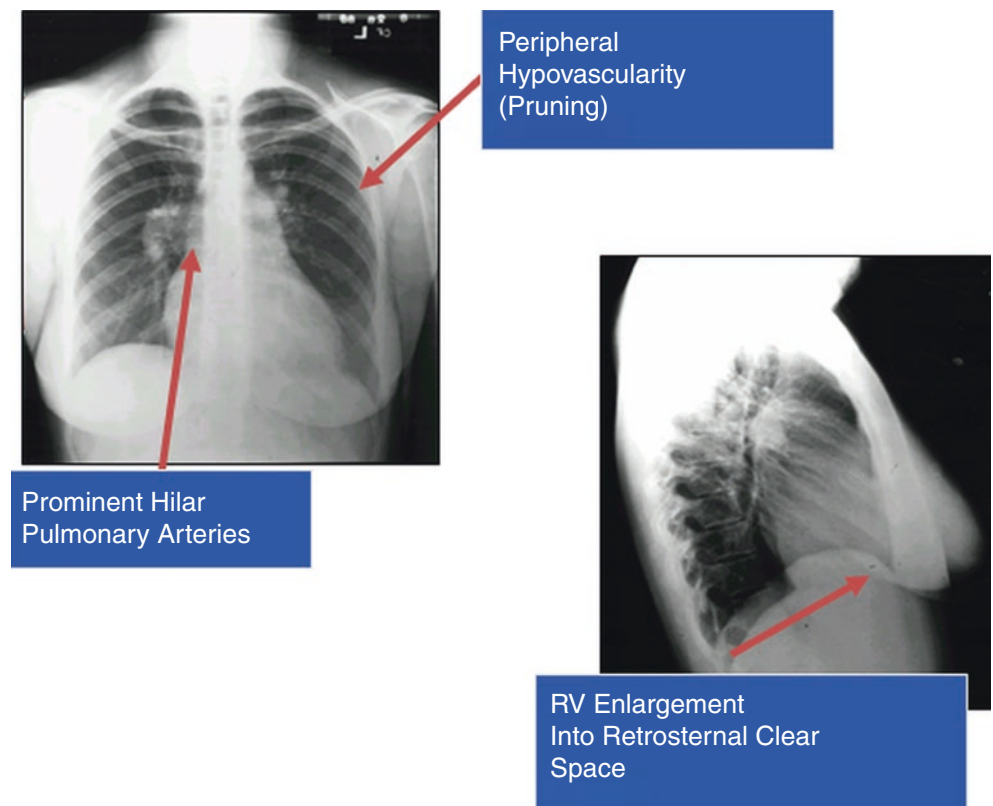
Chest x-ray in PH. Typical changes include: prominent hilar pulmonary arteries, peripheral pruning or hypovascularity and RV enlargement into retrosternal clear space (lateral view)
